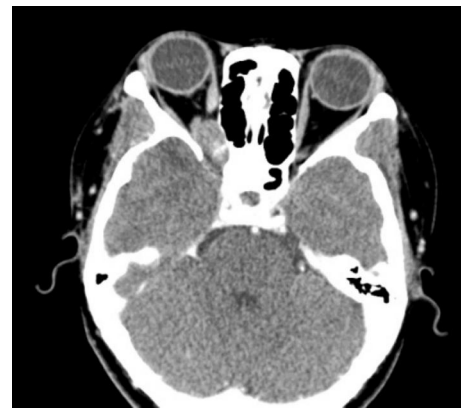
CT imaging demonstrated an inferior intraconal tumor deep in the orbital apex about 11×15–mm² in size, and changes as a result of transcranial surgery were also observed.
